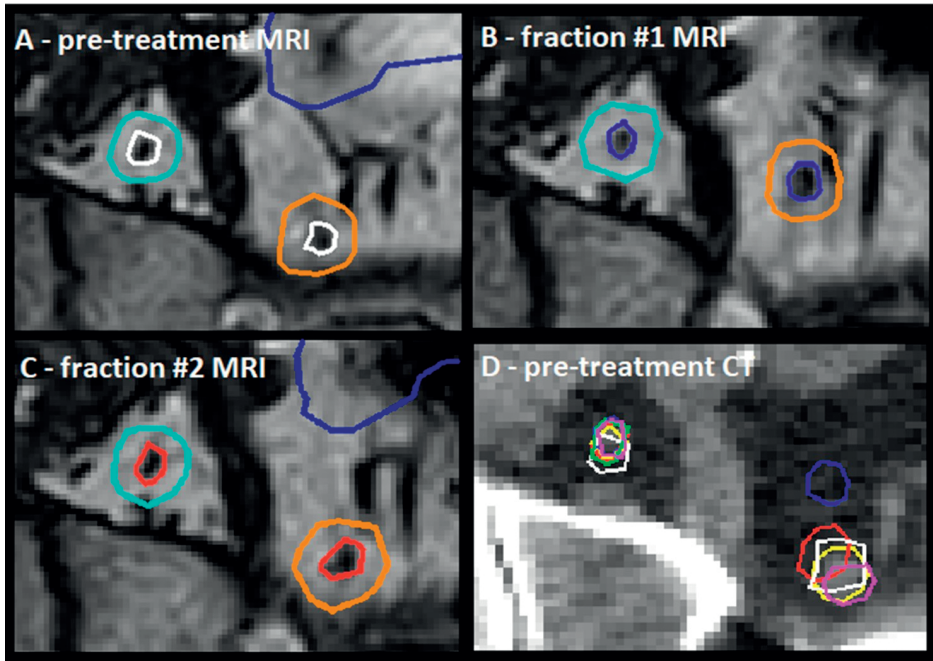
A depicts the pre-treatment situation on MRI and B and C show the online MRI and GTV and PTV contours of two targets (CBCT backup plan with PTV margins of 8 mm for these two targets, due to distance from isocenter/third target) in a multiple lymph node case for fraction one and two, respectively. In fraction one a large variation can be observed in the Euclidean distance between the center of gravities of both targets which decreased from 34.8 mm to 30.6 mm for this particular case because of bowel (dark-blue) influence. D depicts the pre-treatment CT with the online GTV contours for each fraction. The white contour shows the target in pre-treatment situation and the colored contours each represent the contours used in one of the five online fractions and correspond to those in the MRI images.
